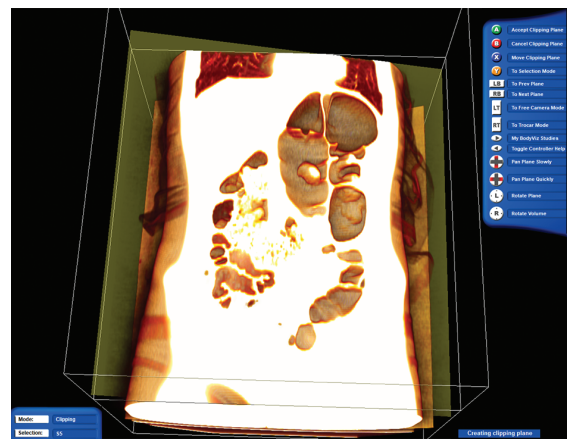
3D reconstruction of the CT study created in BodyViz® software
